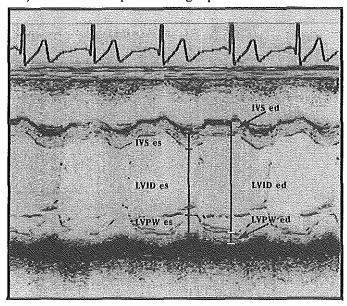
Example of left ventricular (LV) echocardiographic M-mode trace. Cursor positions for end-diastolic (ed) and end-systolic (es) measurements, just below the mitral valve, are indicated. IVS=interventricular septum; LVID=LV internal diameter; PW=LV posterior wall.
